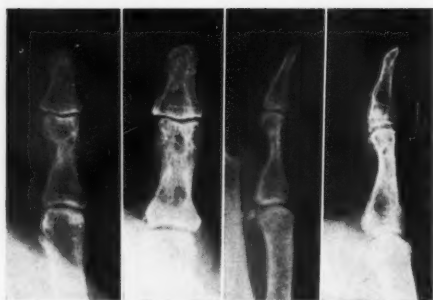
Case 5: Giant-cell tumor of thumb before and fifteen years after curettage and roentgen therapy. Note soft tissue swelling.
